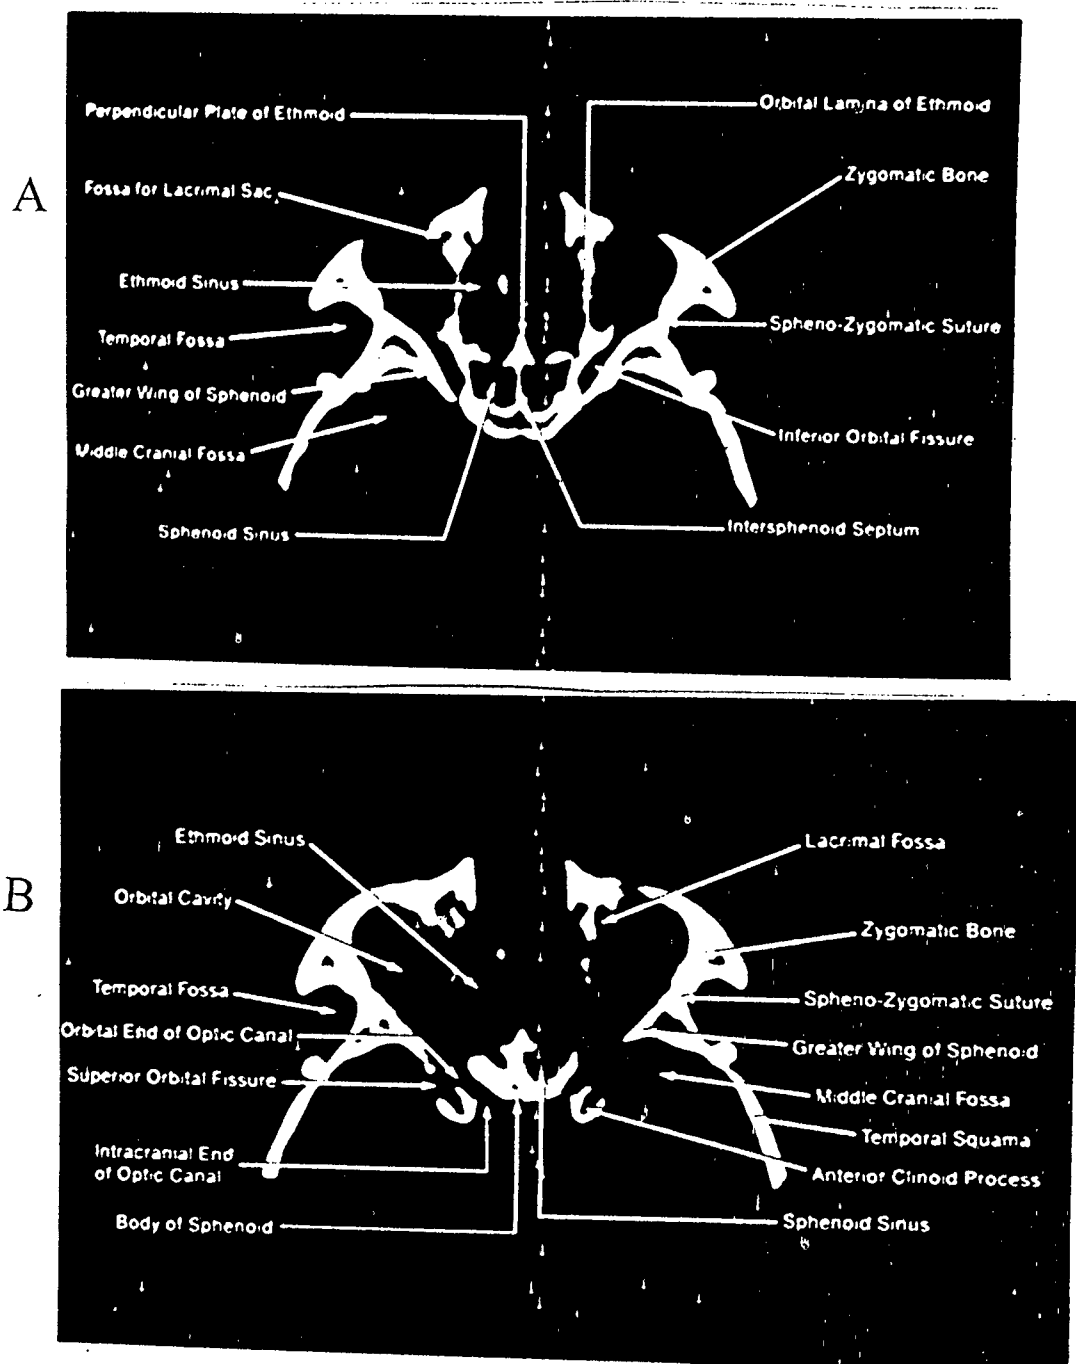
Bone setting:CT appearance of orbital bony details. Axial cuts .
